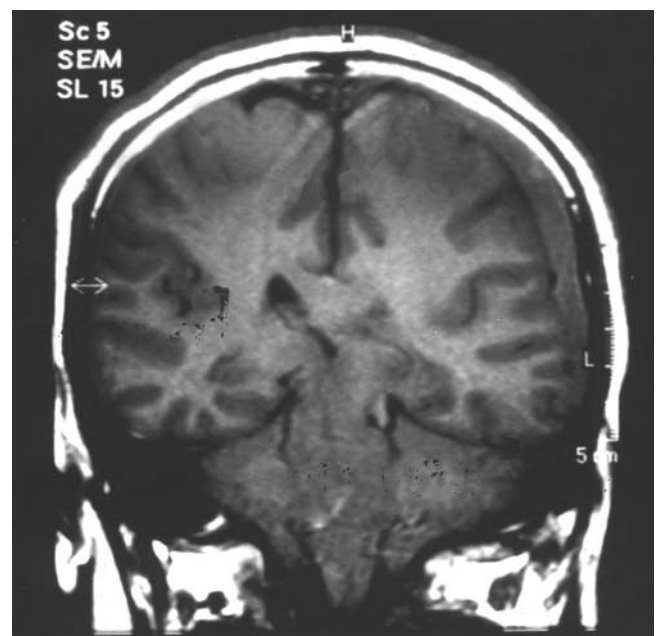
T1-weighted coronal MR image performed 10 days after diagnostic lumbar puncture, showing the existence of subdural hematoma compressing the left cerebral hemisphere and dislocating and deforming the corresponding cerebral peduncle subtentorially. Note the failure to visualize the left lateral ventricle
